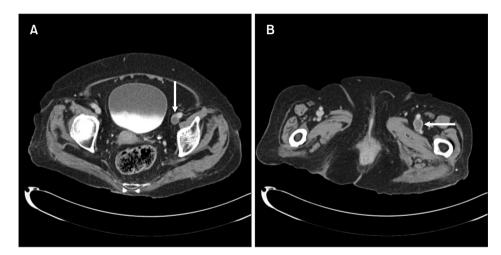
Computed tomography angiograms of proximal deep vein thrombosis (DVT). (A) The arrow indicates DVT in the left external iliac vein. (B) The arrow indicates DVT in the left common femoral vein.
